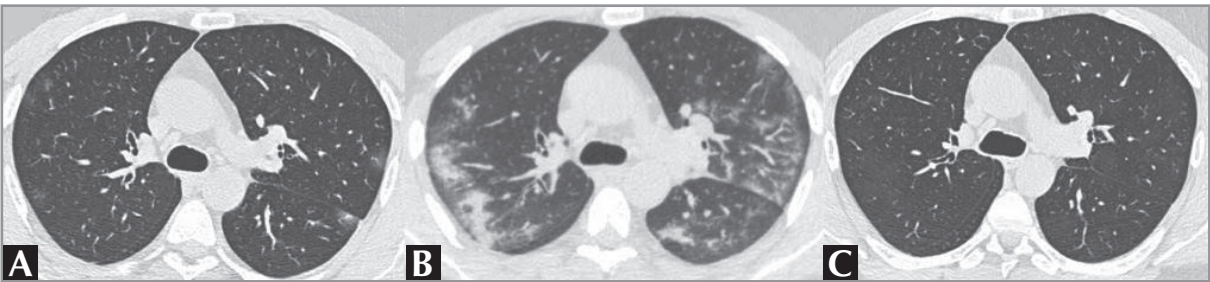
CT findings of patients with partial and complete response after corticosteroid treatment is shown in Figure 1 for the activation phases.
